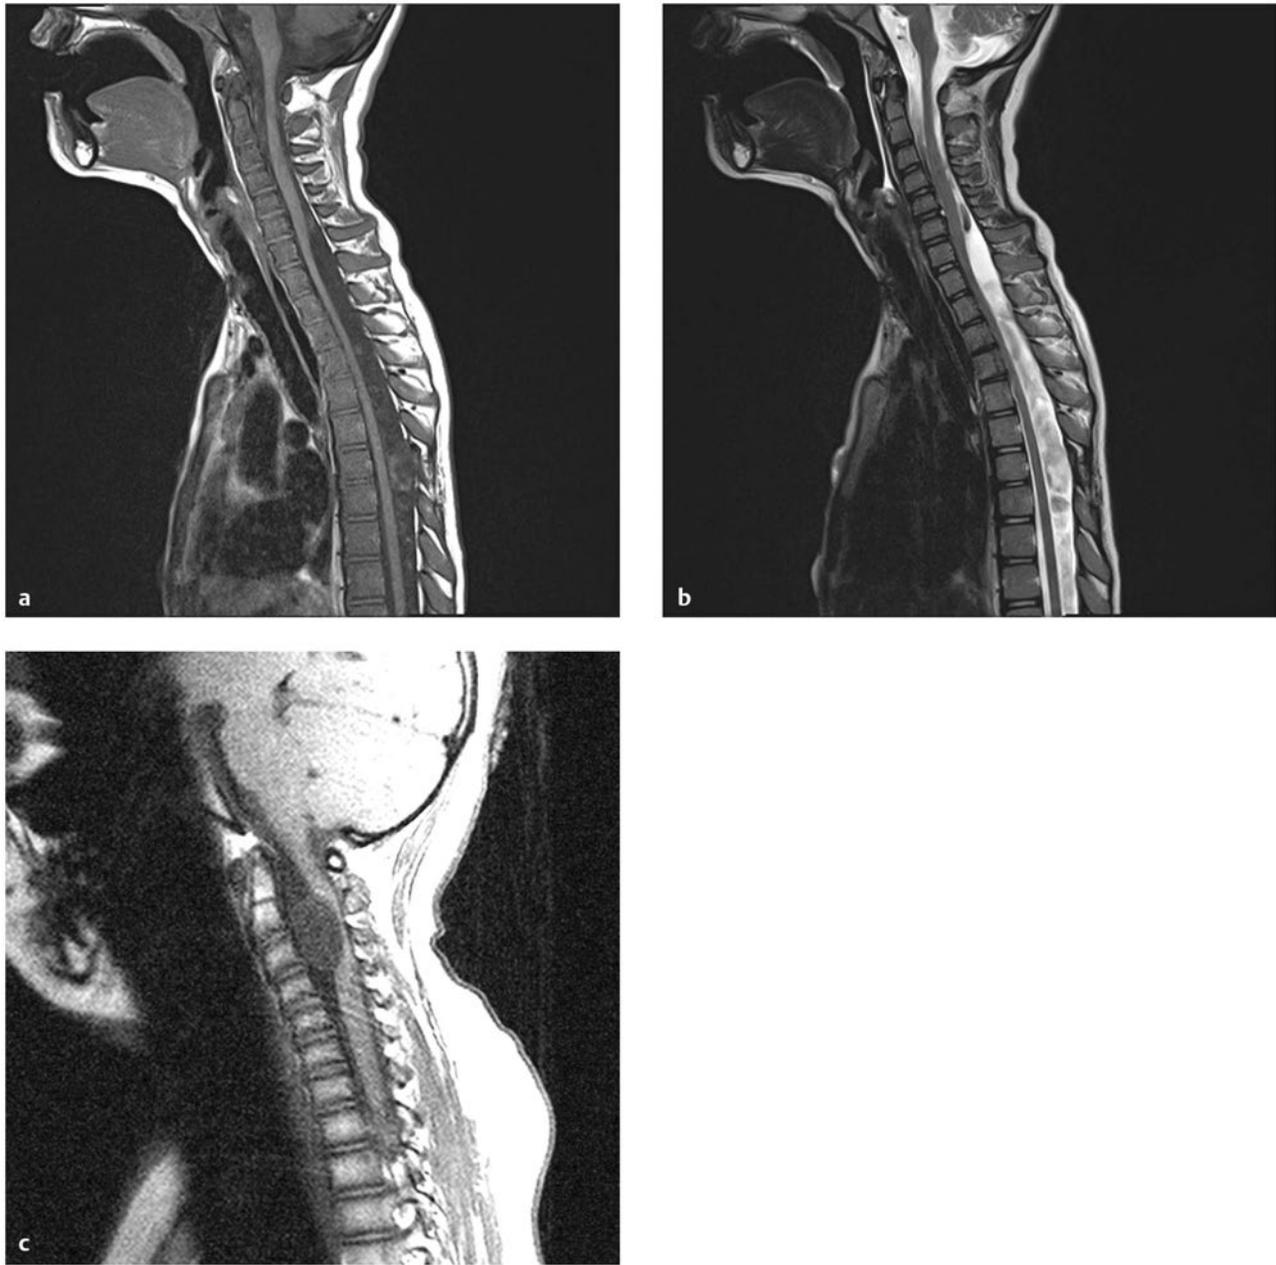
Arachnoid cyst. (a) Arachnoid cysts are typically located dorsal to the cord, like this cervicothoracic lesion, with the cyst fluid slightly hypointense to cerebrospinal fluid (CSF) on T1-weighted sequences. Mild cord compression is seen. (b) On the T2-weighted sequence, the cyst fluid is hyperintense to CSF, and flow voids can be seen above and below the cyst, helping to define its extent. (c) The surgically proven arachnoid cyst shown is unusual in its location, anterior to the cord, and in its signal characteristics, which are slightly hyperintense to those of CSF. The flow void artifact (bottom of cyst) helps to define the lower cyst margin.
